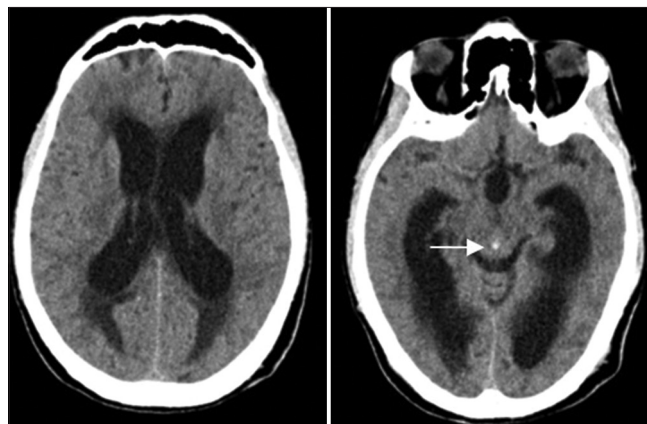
Computed tomography on admission shows enlarged lateral ventricles (left). A small blood clot is seen blocking the aqueduct (white arrow) along with dilatation of the third ventricle (right)
